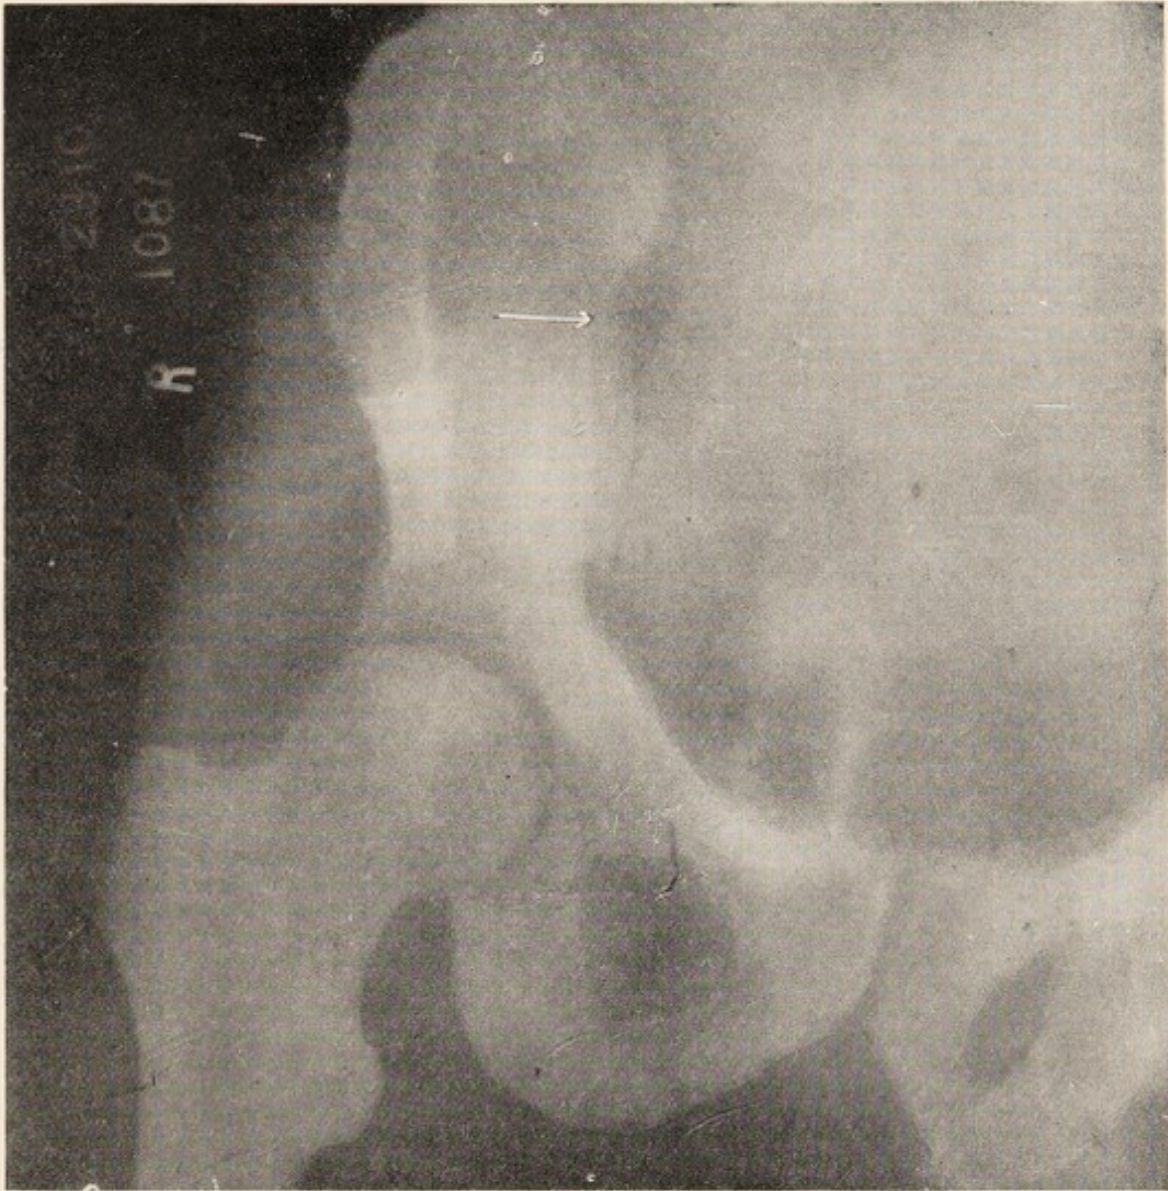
X-ray showing a focus in the upper portion of the sacro-iliac joint in a patient, aged 45, with "sciatica."
